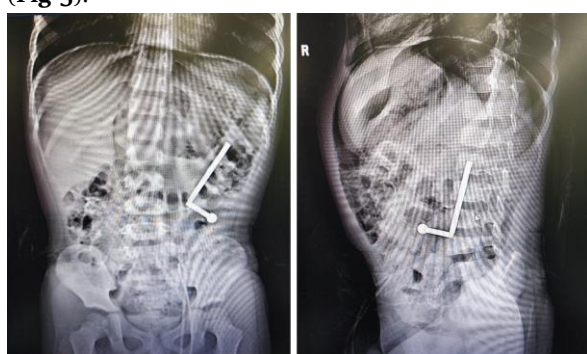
Radiographs were repeated, an inverse "L" shaped metal foreign body was found in the left middle and upper abdomen
